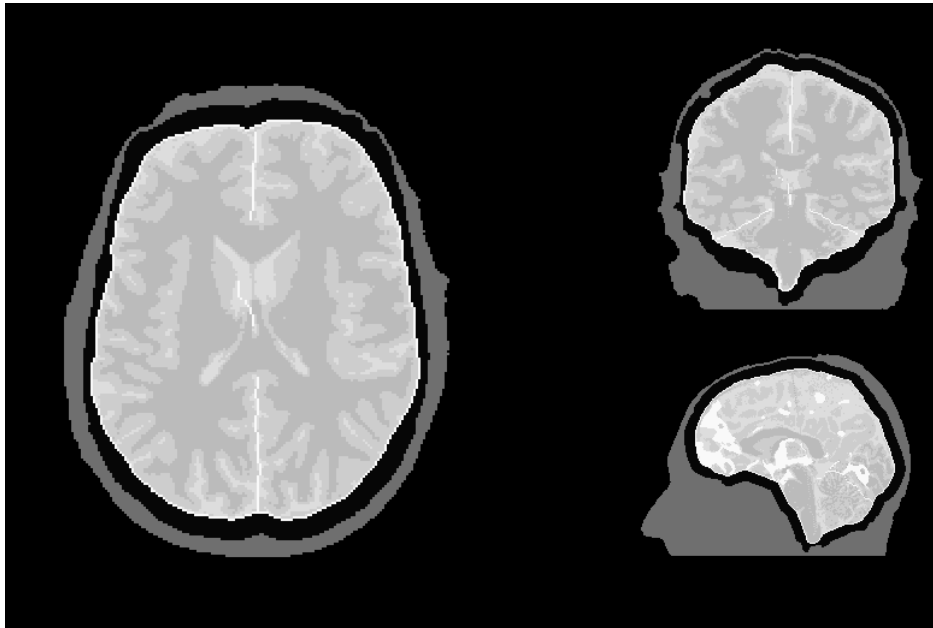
Segmentation of an example MRI dataset: Skull (black), extracranial tissue (dark grey), white matter (grey), grey matter (light grey), CSF(white)
